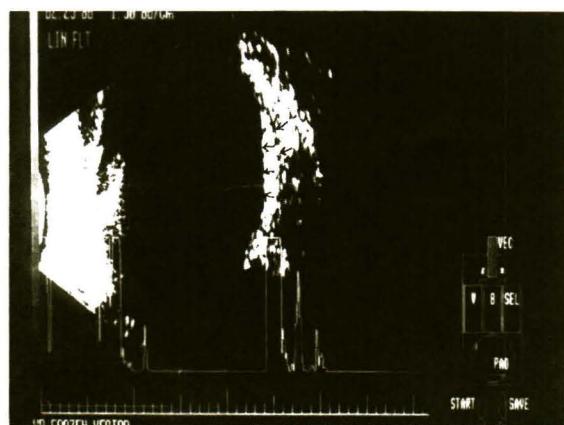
Patient 3. Ultrasonography of the lesion in the left eye shows the characteristics of a high reflectivity echogenic mass with a plano-convex configuration (arrows).
